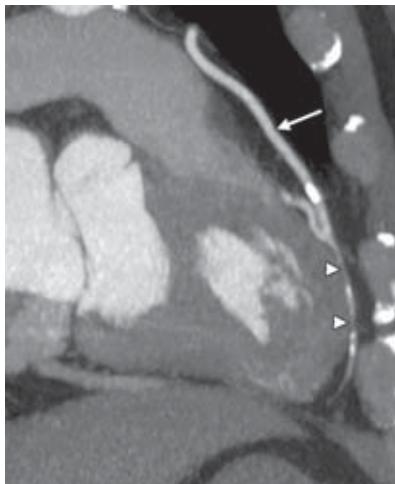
Computed tomography angiography of a post coronary artery bypass graft patient showing patent left internal mammary artery—left anterior descending artery (LAD) graft (arrow) with diffuse distal LAD disease (arrowheads).
